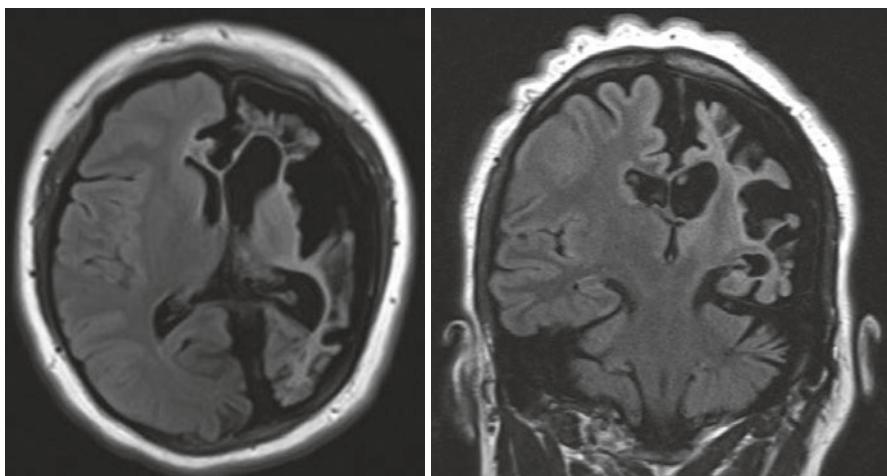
MRI T1 axial (left) and coronal (right) images of a patient with drug-resistant focal epilepsy and history of congenital stroke. Note dilatation of the left lateral ventricle (ex-vacuo hydrocephalus) as a result of brain atrophy
